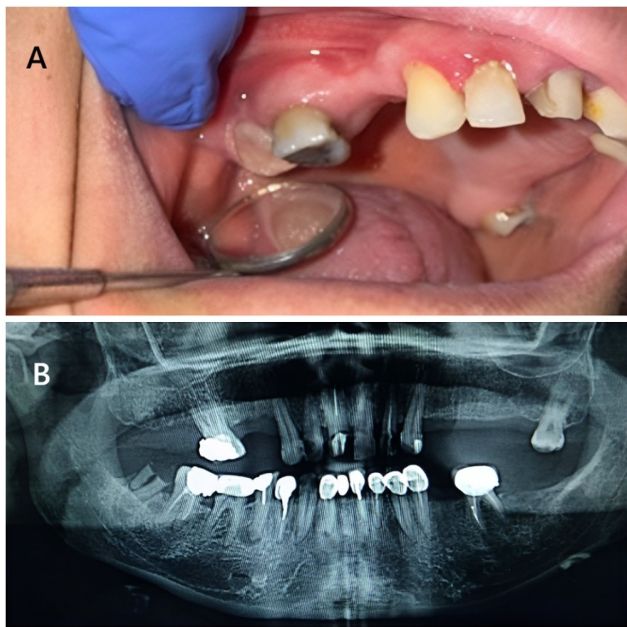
(A) Clinical photograph showing a well-defined, solitary, sessile, oval growth on the buccal gingiva adjacent to the right maxillary second molar (tooth #17). (B) Panoramic X-ray showing no bony involvement of the lesion.
